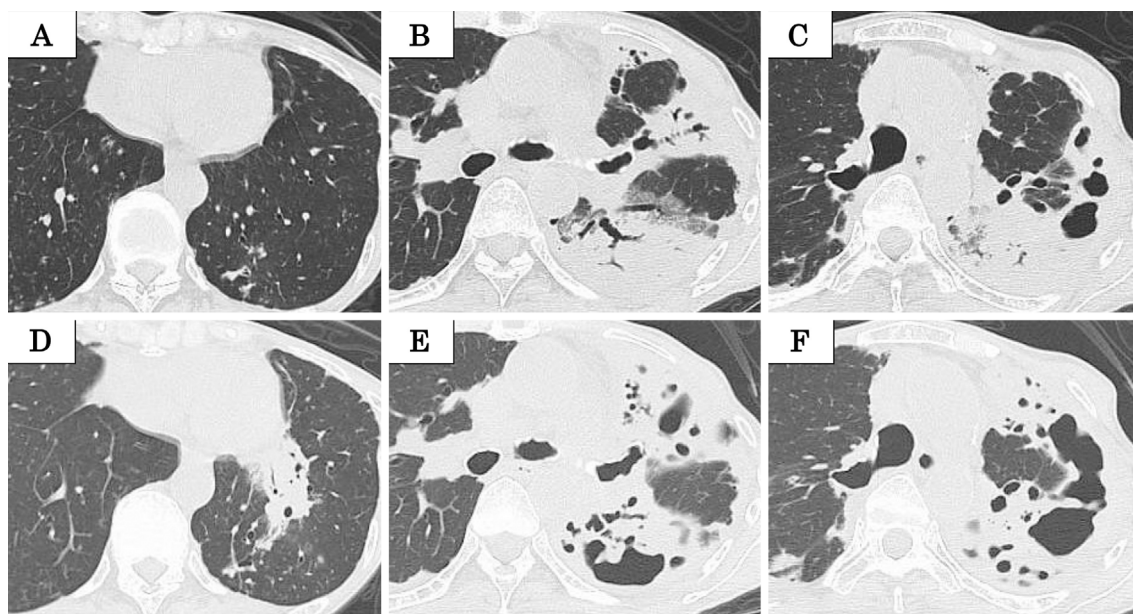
Chest computed tomography (CT) performed in February 2016 (D, E, F) demonstrates consolidations with cavitory lesions and bronchiectasis in the left upper lobe, which appear to have worsened on chest CT performed in September 2015 (A, B, C).
